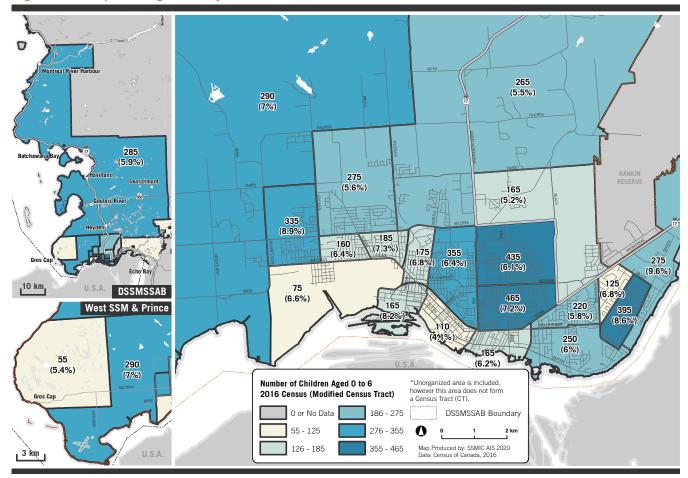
Total Population Aged 0 to 6 by Census Tract (CT), DSSMSSAB Area, 2016
